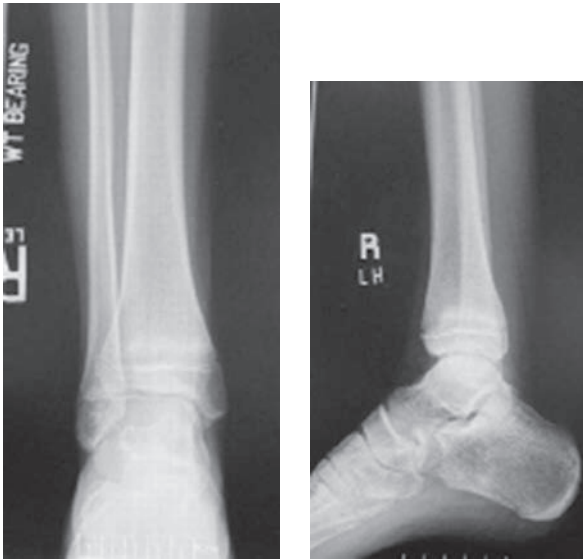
Distal tibia stress fracture. A 15-year-old male with 6 weeks of pain while running cross-country. Anteroposterior radiograph shows callus formation in the distal tibia metaphysis.
